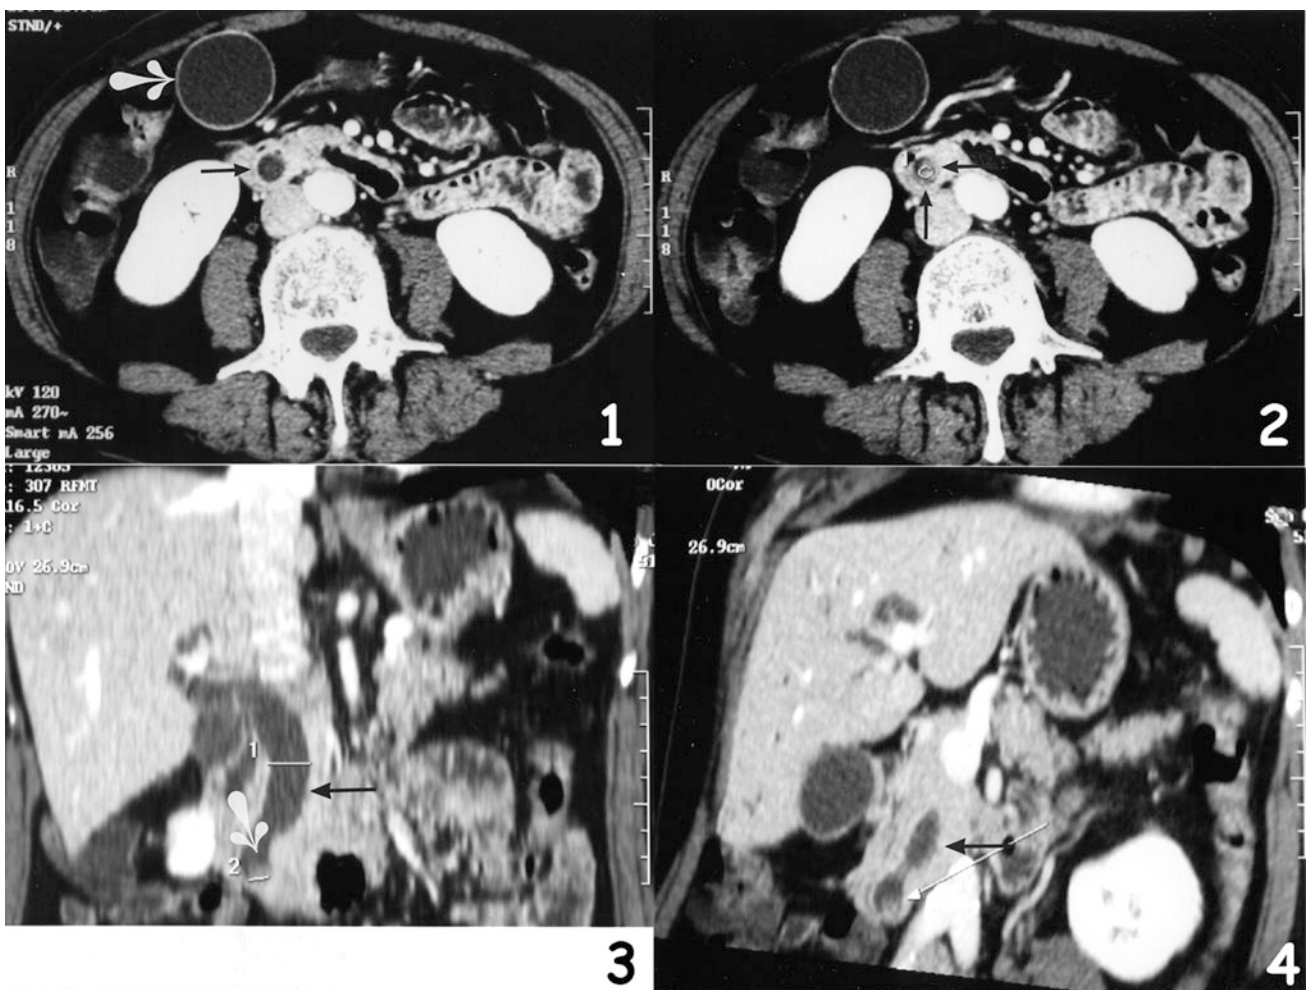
Carcinoma of the papilla of Vater. Enhanced CT reveals a dilated gallbladder (white arrow) and a common bile duct (black arrow) (1) with an enhancing small mass in the ampullary area
